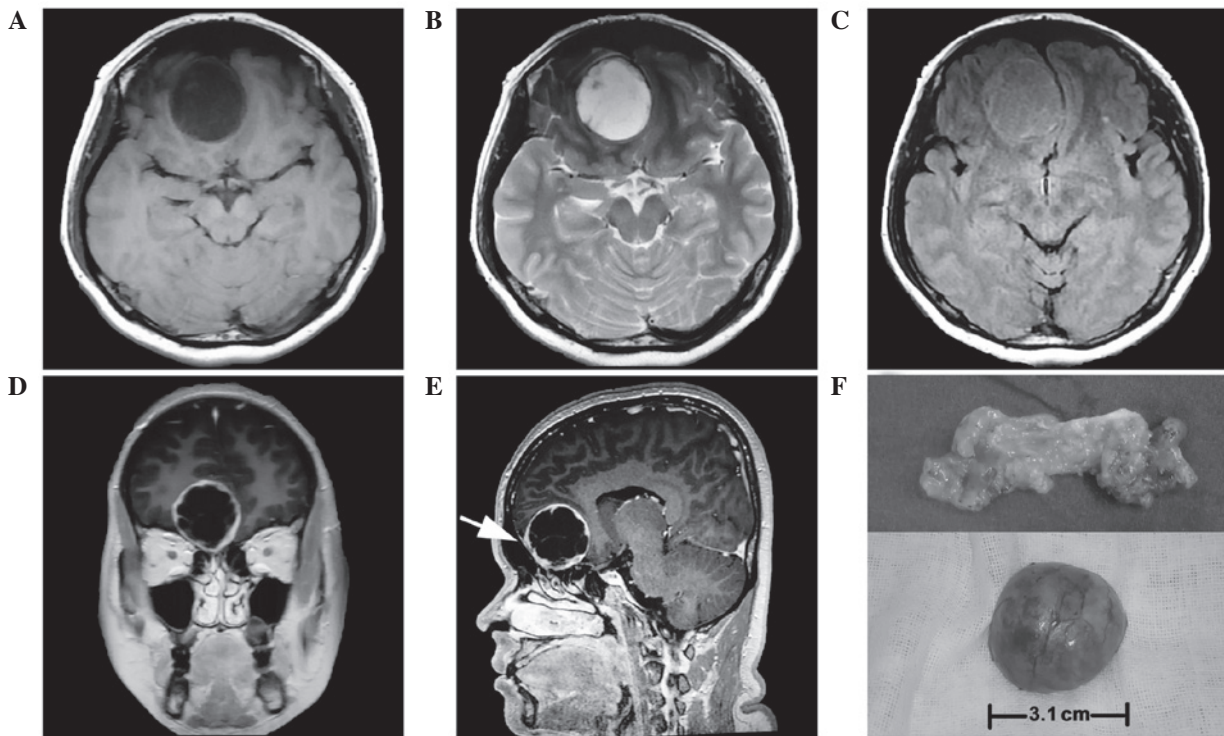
MRI of the brain. (A) Homogeneous hypointensity was observed on T1-weighted images (axial view). (B) Homogeneous hyperintensity was observed on T2-weighted images (axial view). (C) Homogeneous isointensity was observed on fluid-attenuated inversion recovery image (axial view). (D) Enhanced MRI on coronal view showing that the bone of the frontal base was slightly depressed toward the nasal cavity. (E) MRI scan showing that the basilar part of the tumor was tightly connected to the endocranium, mimicking dural tail sign on sagittal view (arrow). (F) Top: The tumor appeared fat-like inside upon dissection, as it was yellow and soft. Bottom: The tumor was covered by a smooth capsule. MRI, magnetic resonance imaging.
